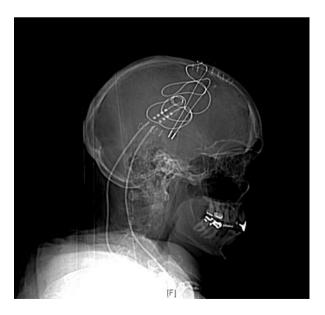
Radiograph with bilateral DBS leads
